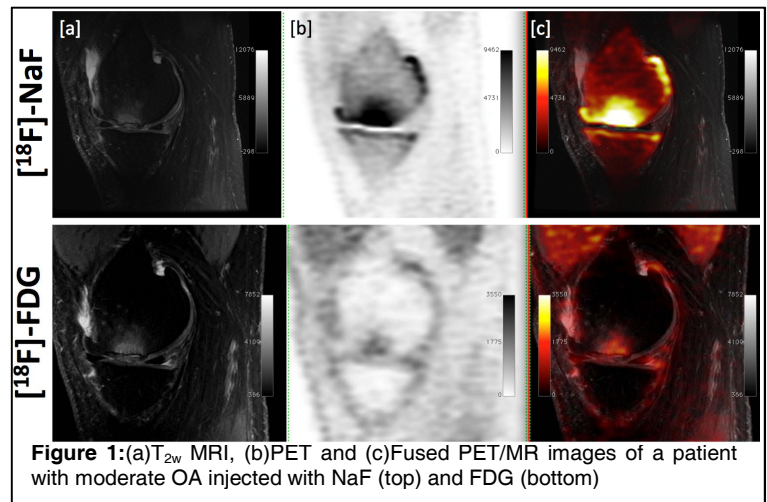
(a)T_{2w} MRI, (b)PET and (c)Fused PET/MR images of a patient with moderate OA injected with NaF (top) and FDG (bottom)
